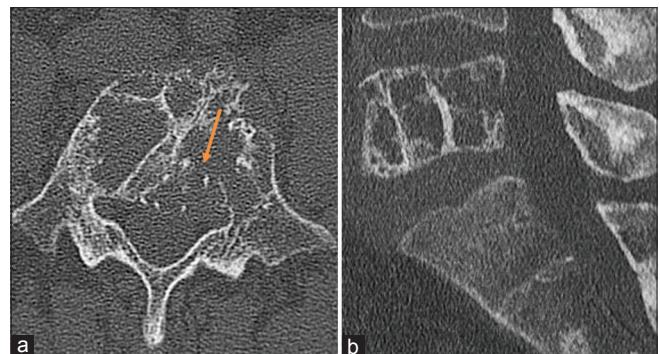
Lumbar computed tomography-scan shows an extensive osteolytic lesion of the body and left pedicle of L5 with involvement of the posterior wall (a) (arrow). The "Polka-dot" signs are suggestive of a vertebral hemangioma (b)
